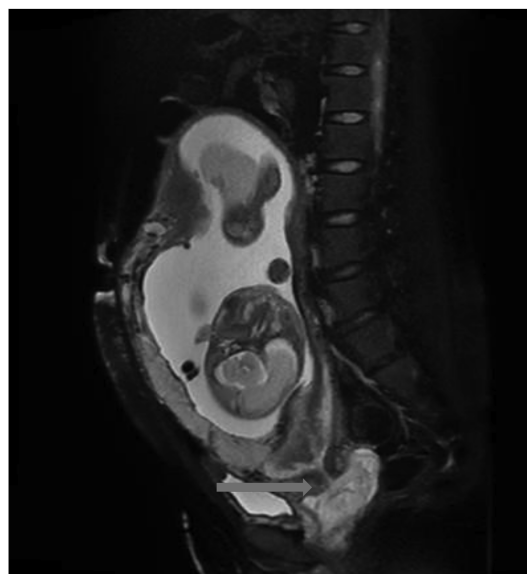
Magnetic resonance imaging revealed placenta previa, the bleeding between the placenta and vagina looks like a “sandglass” (red arrow).
